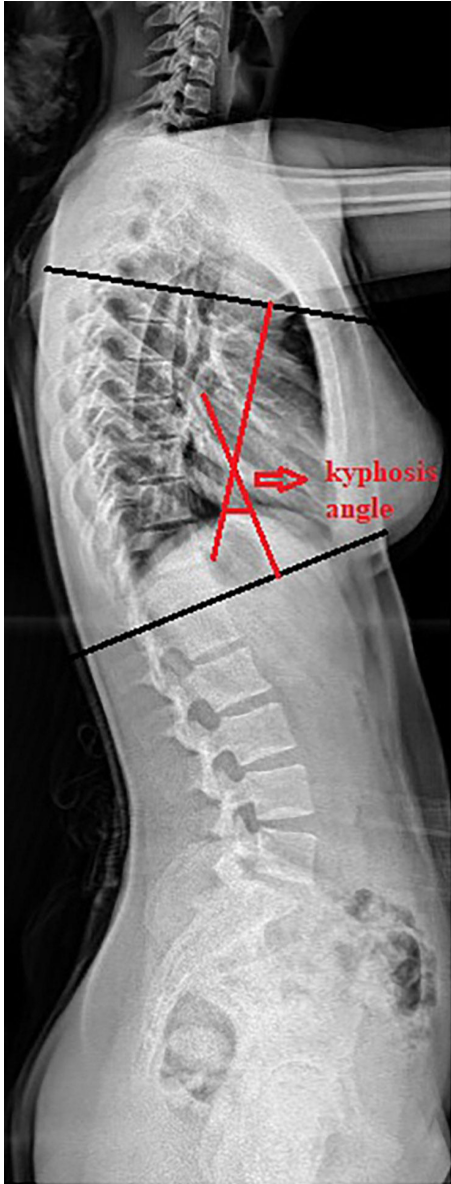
Kyphosis angle measured between the upper endplate of T5 and the lower endplate of T12 on the lateral radiograph.¹⁶ A kyphosis angle of $<10^\circ$ is considered hypokyphosis, a kyphosis angle $>40^\circ$ is considered hyperkyphosis, and an angle between 10° and 40° is considered normal.³⁵
